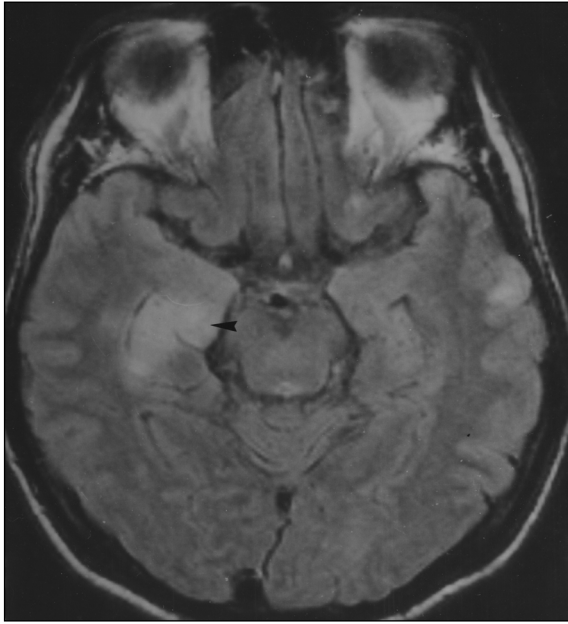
40-year-old man with acute Nipah encephalitis. Fluid attenuated inversion recovery MR image shows confluent involvement of temporal lobe (arrowhead).
